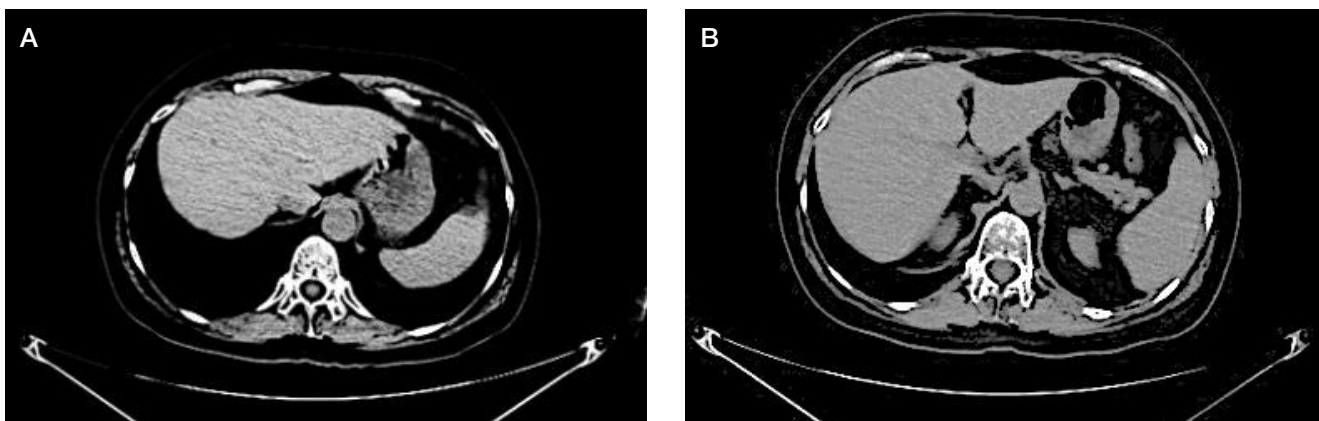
A, B. Abdominal CT, 03.10.2023. Metastatic foci in the liver not visualized clearly since 01.01.2023 (positive dynamics)
